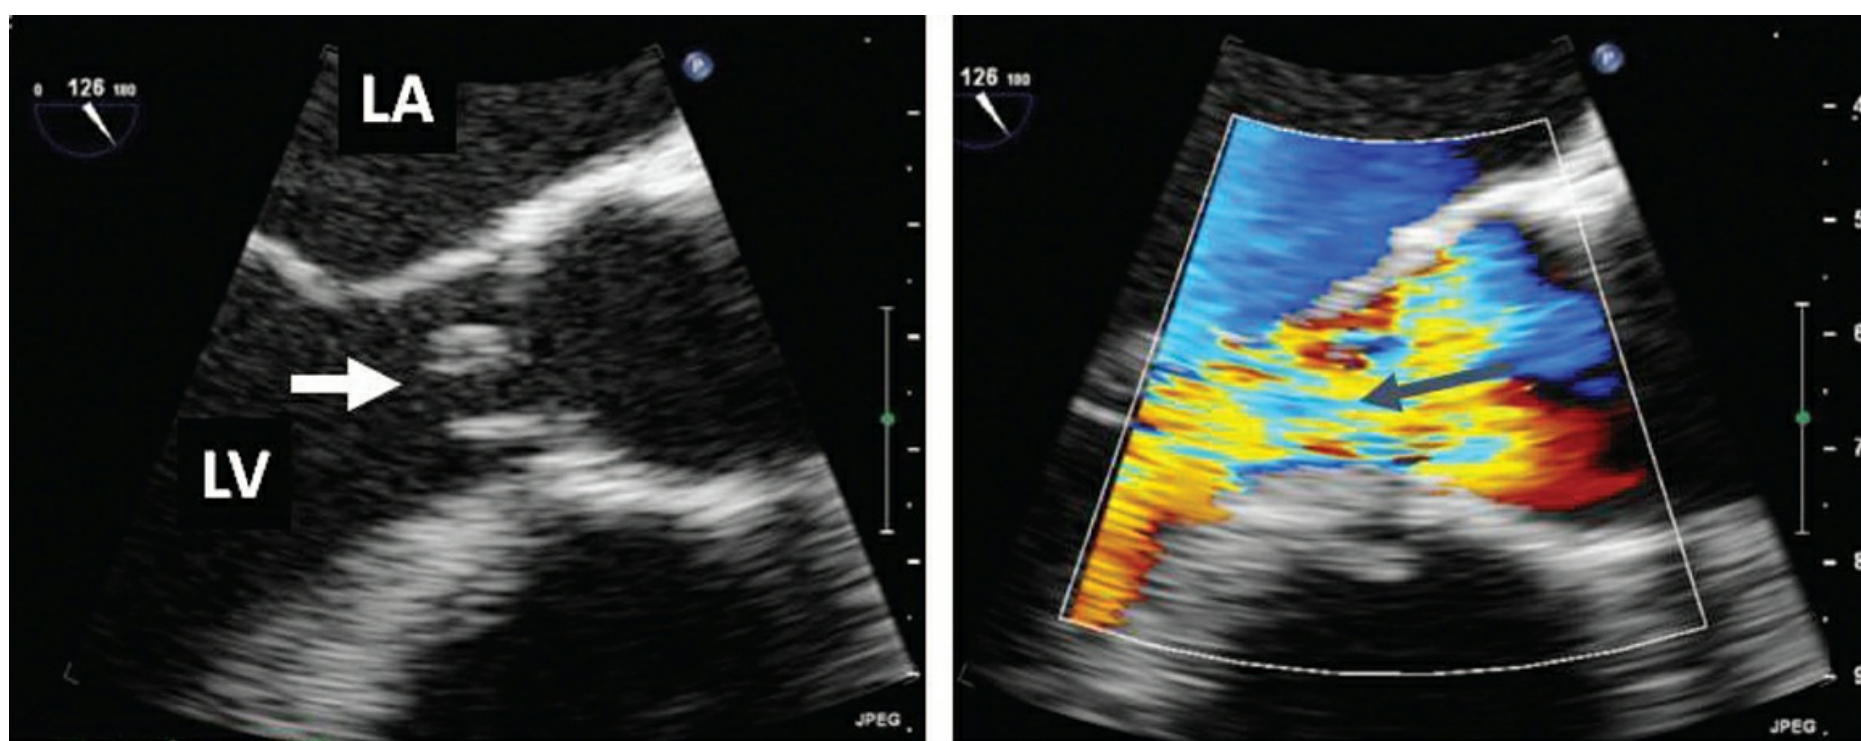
Transesophageal view depicting the anomaly (white arrow). Color Doppler shows severe aortic regurgitation, with the color jet occupying all of the left ventricle outflow tract. LA, left atrium; LV, left ventricle.
